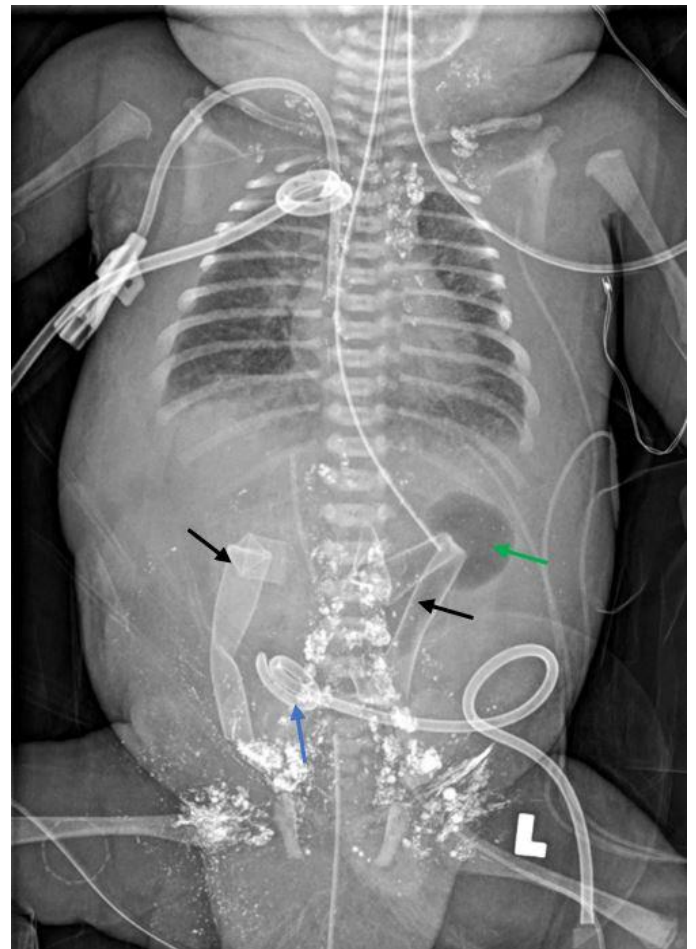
Chest and Abdomen Radiograph of Pneumoperitoneum in a 1-Month-Old Girl on Day 3 of Admission.
